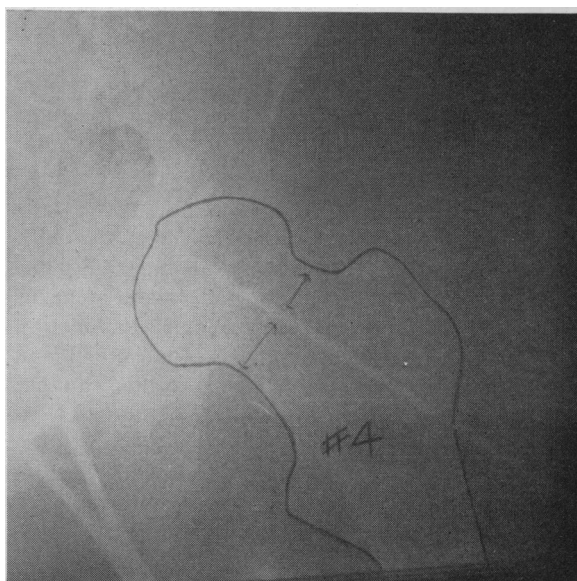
Placement of pin in an intertrochanteric fracture in a 73-year-old woman. This was the only x-ray film made during operation.
